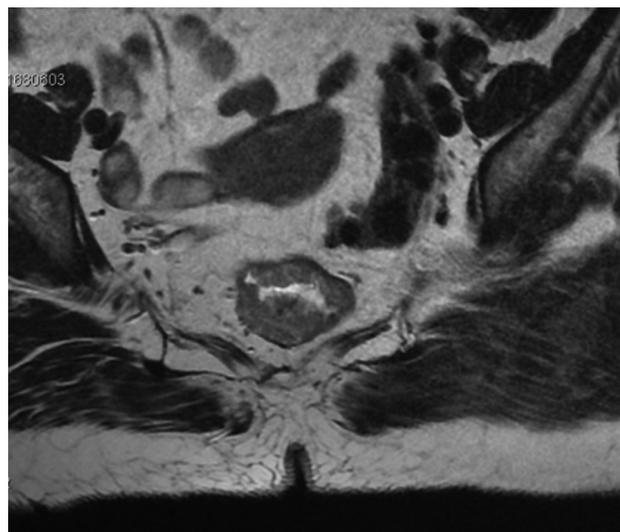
Axial section on magnetic resonance imaging showing a vegetative lesion in the middle part of the rectum.
